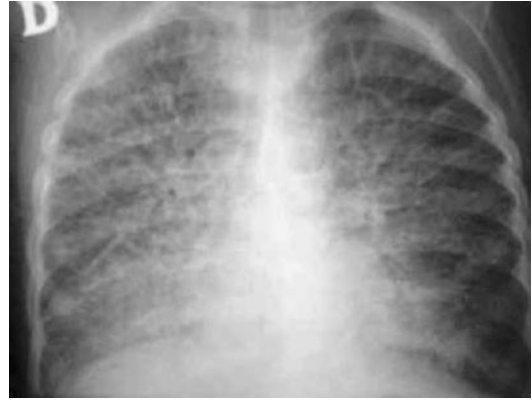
Miliary tuberculosis. AP chest X-ray of an infant with no BCG vaccine and intrafamilial contact with an adult with bacilliferous tuberculosis. Diffuse bilateral granular compromise can be observed, consistent with miliary tuberculosis
